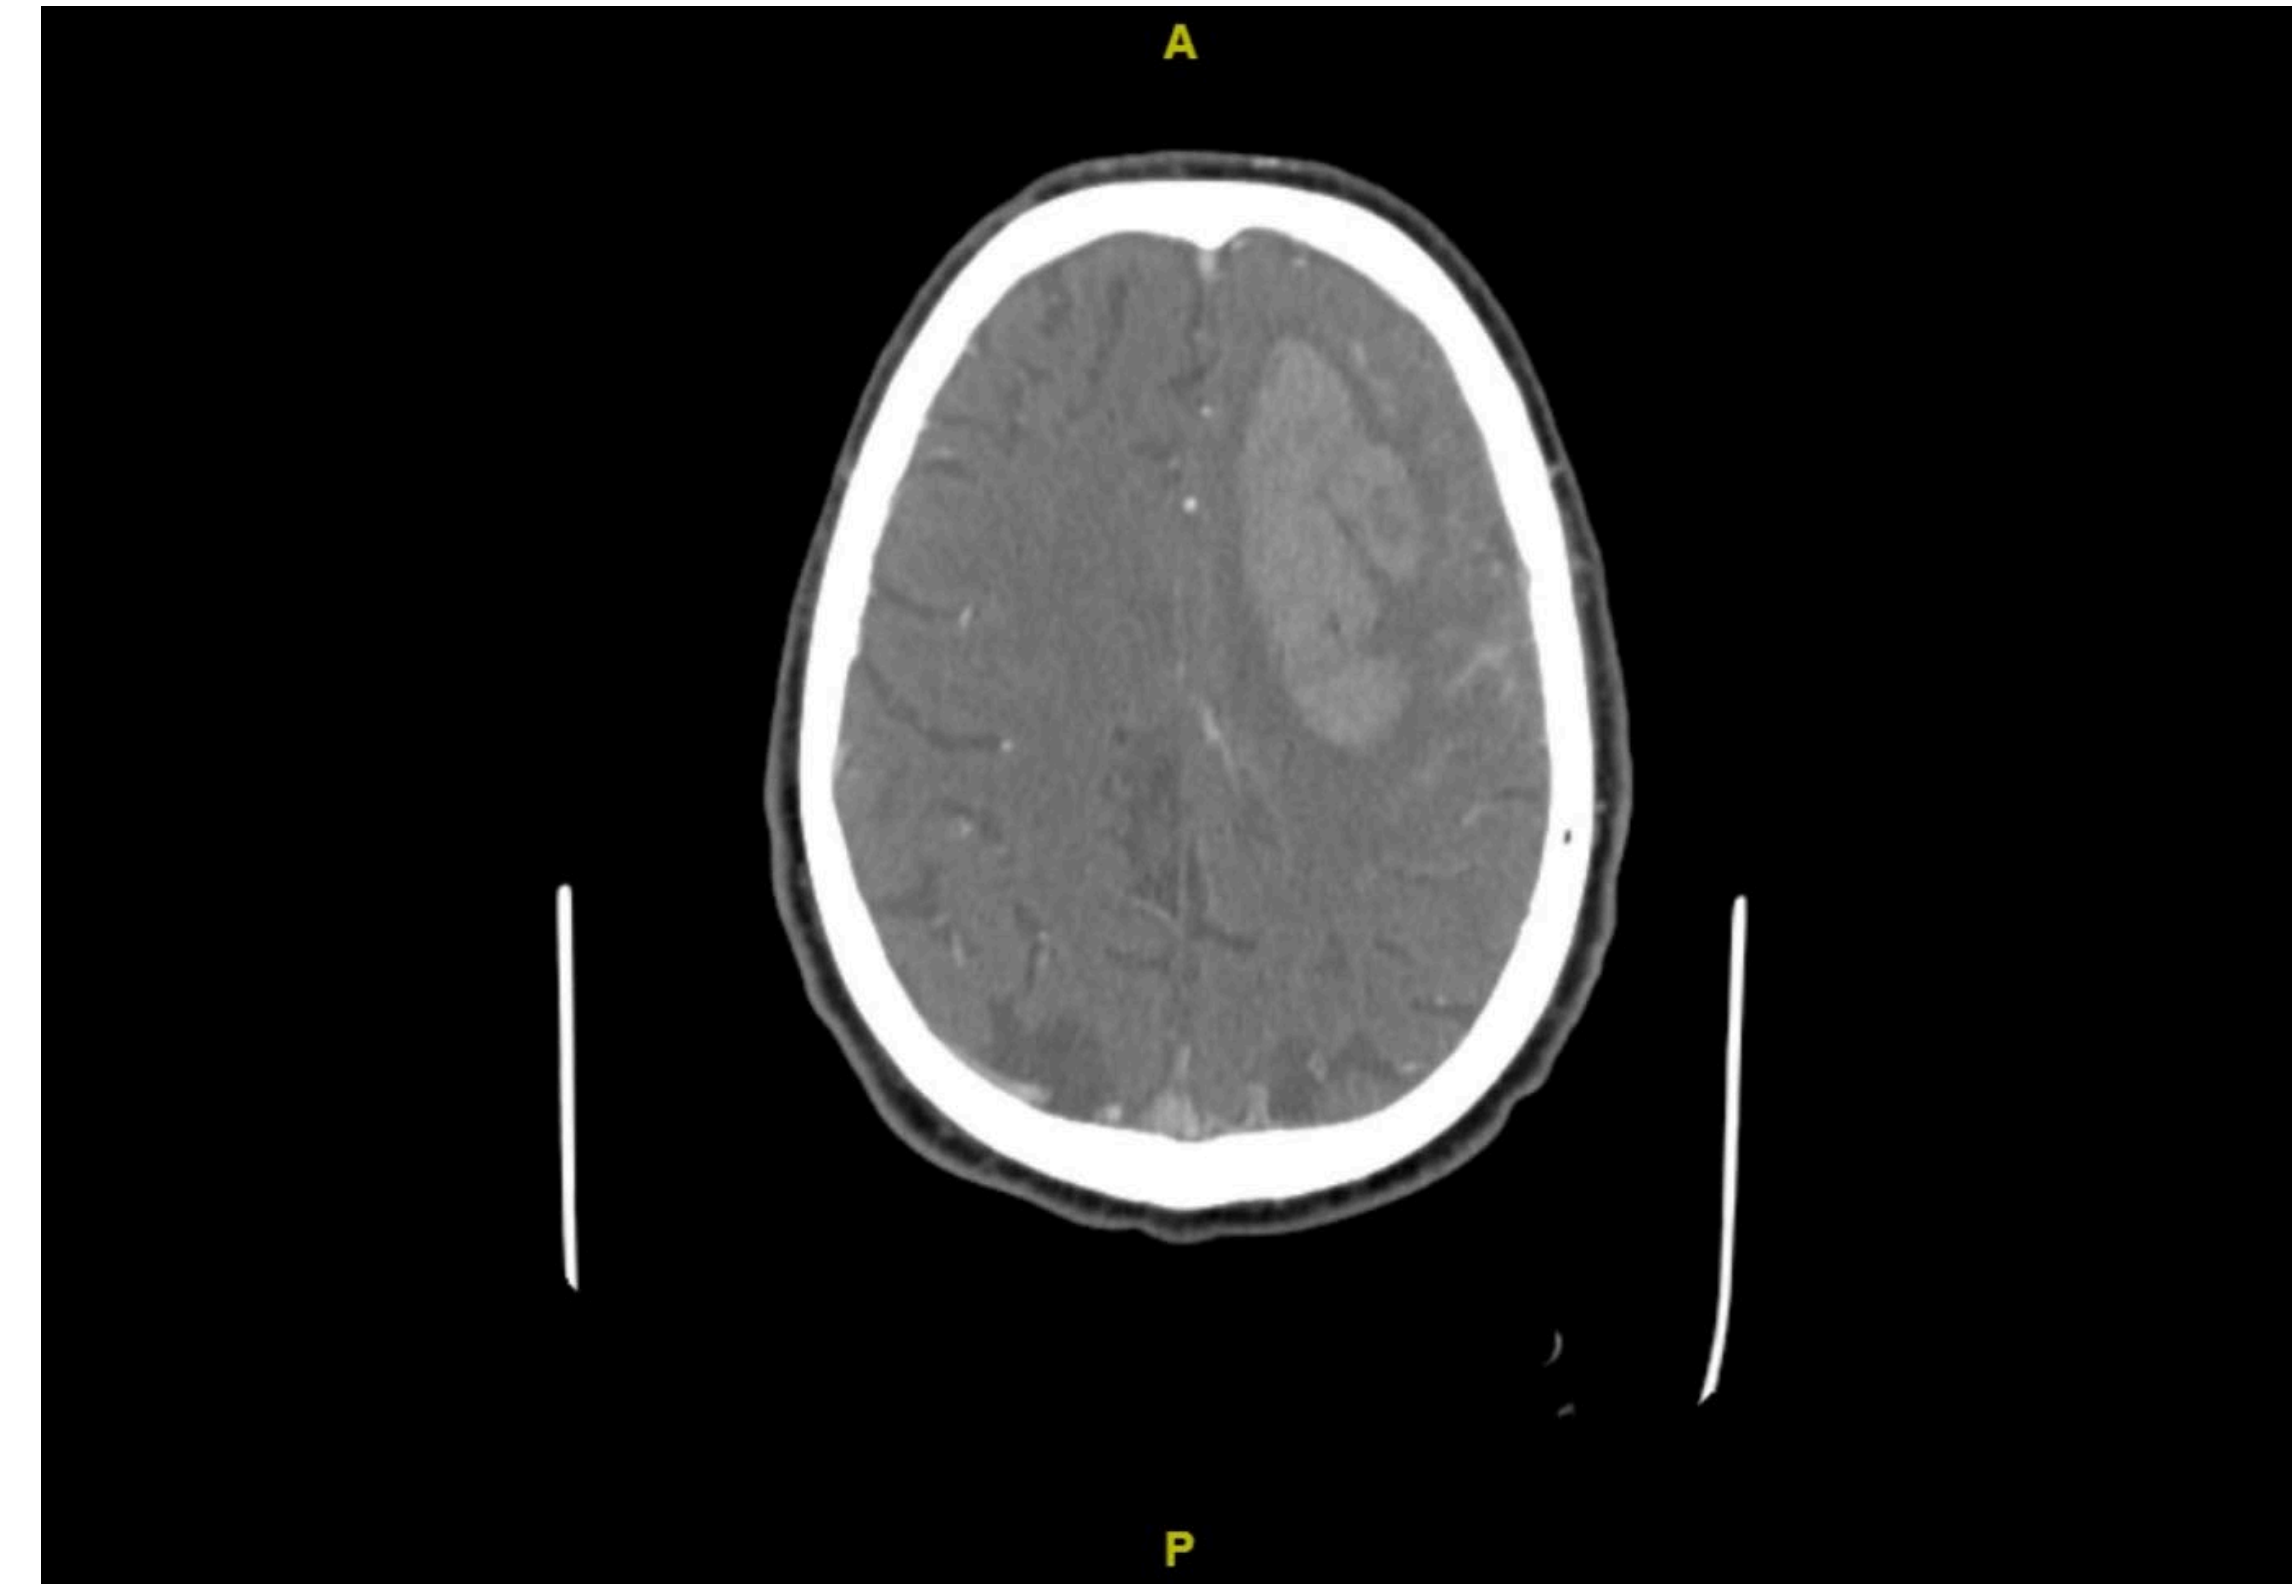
Non-contrast CT of the head demonstrating left ICH and leptomenigeal hyperintensities known as the “ivy sign.”
